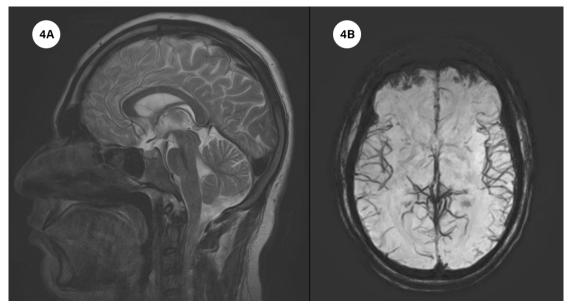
& 4B). T2 Weighted MRI Sagittal Section and Axial SWI Image Reveal No Significant Abnormality.
